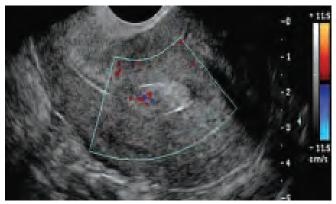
Color Doppler scan of an endometrial polyp demonstrating stalk vessels
